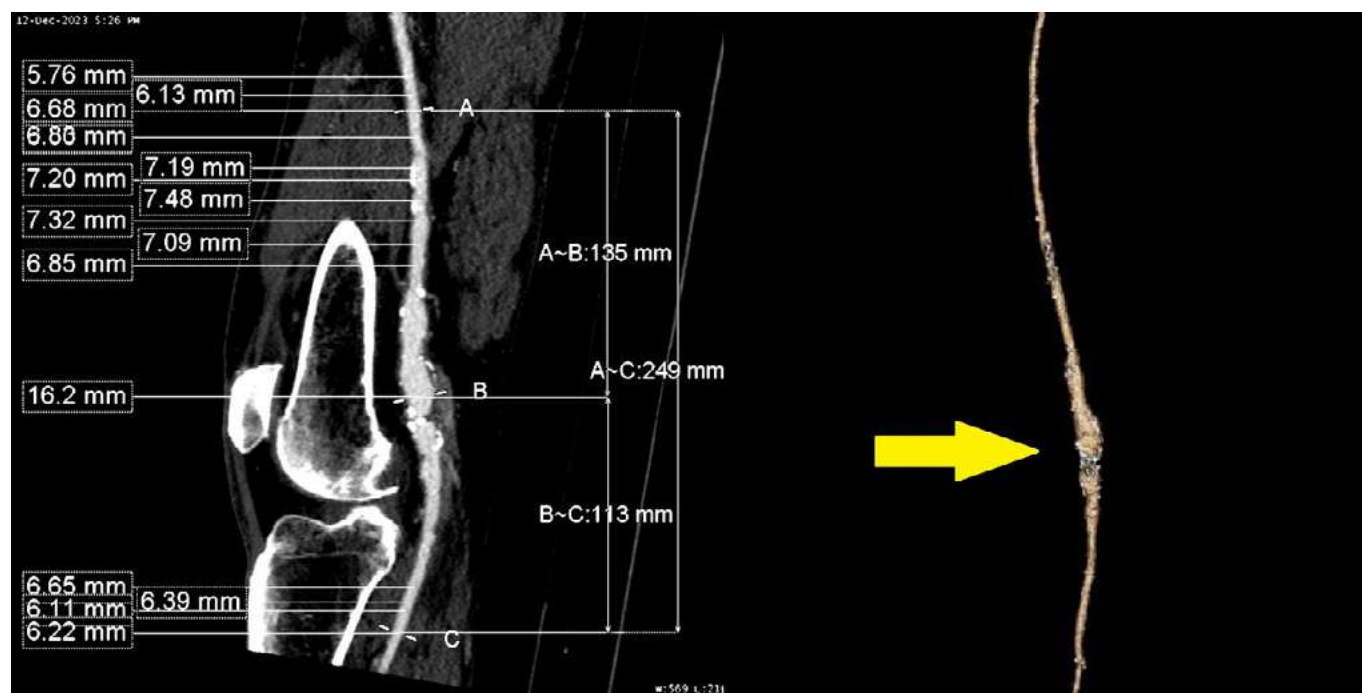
Pre-operative CTA work-up prior to elective endovascular repair of left PA aneurysm.
